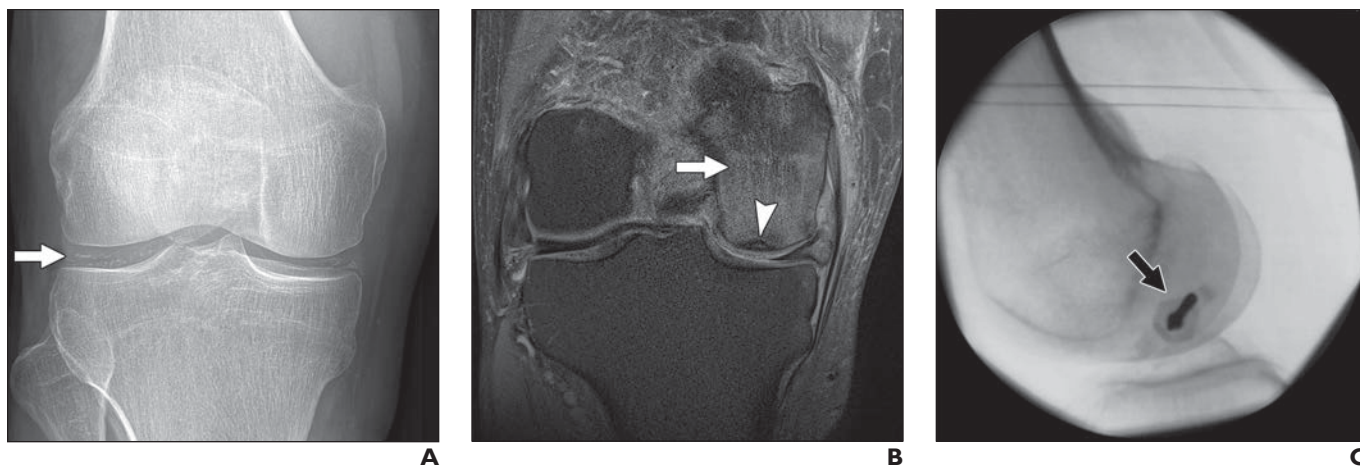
70-year-old man with knee pain on right side. A, Preoperative radiograph shows chondrocalcinosis (arrow) in both menisci. B, Preoperative coronal intermediate-weighted fat-saturated MR image (TR/TE, 2750/24) shows extensive bone marrow edema (arrow) in medial femoral condyle and subchondral linear hypointense fracture line parallel to cortex (arrowhead), which are consistent with insufficiency fracture. C, Intraoperative fluoroscopy image shows needle placement (arrow) for subchondroplasty performed via lateral approach. D and E, Postoperative radiographs show new opacification in medial femoral condyle (black arrowheads) and preexisting chondrocalcinosis (arrow, D). Drill hole is visible on lateral image (E) in center of injected calcium phosphate. Note that there is minor soft-tissue contamination medial to medial femoral condyle (white arrowhead, D) along lateral approach.
